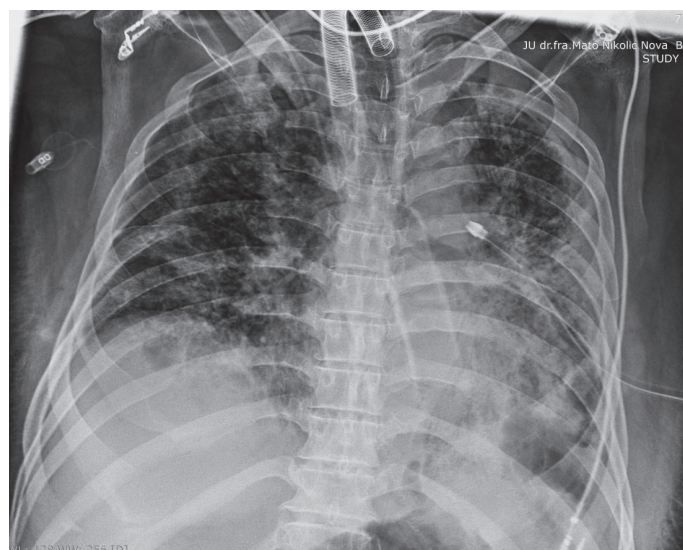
Radiograph of chest organs after chest drain (Source: Author)
